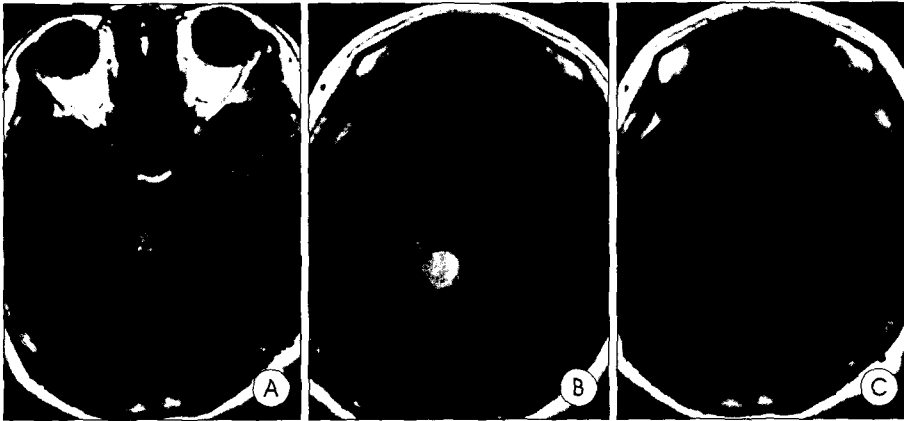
Case 2. A 42-year-old woman developed left paresthesia as a result of hemorrhage from a right midbrain cavernous hemangioma (A). She underwent linear accelerator radiosurgery. At 60 months after radiosurgery, she experiences rebleeding (B). She underwent surgery via a right subtemporal approach to the lateral midbrain. Postoperative magnetic resonance image (C) reveals complete resection of the lesion.
